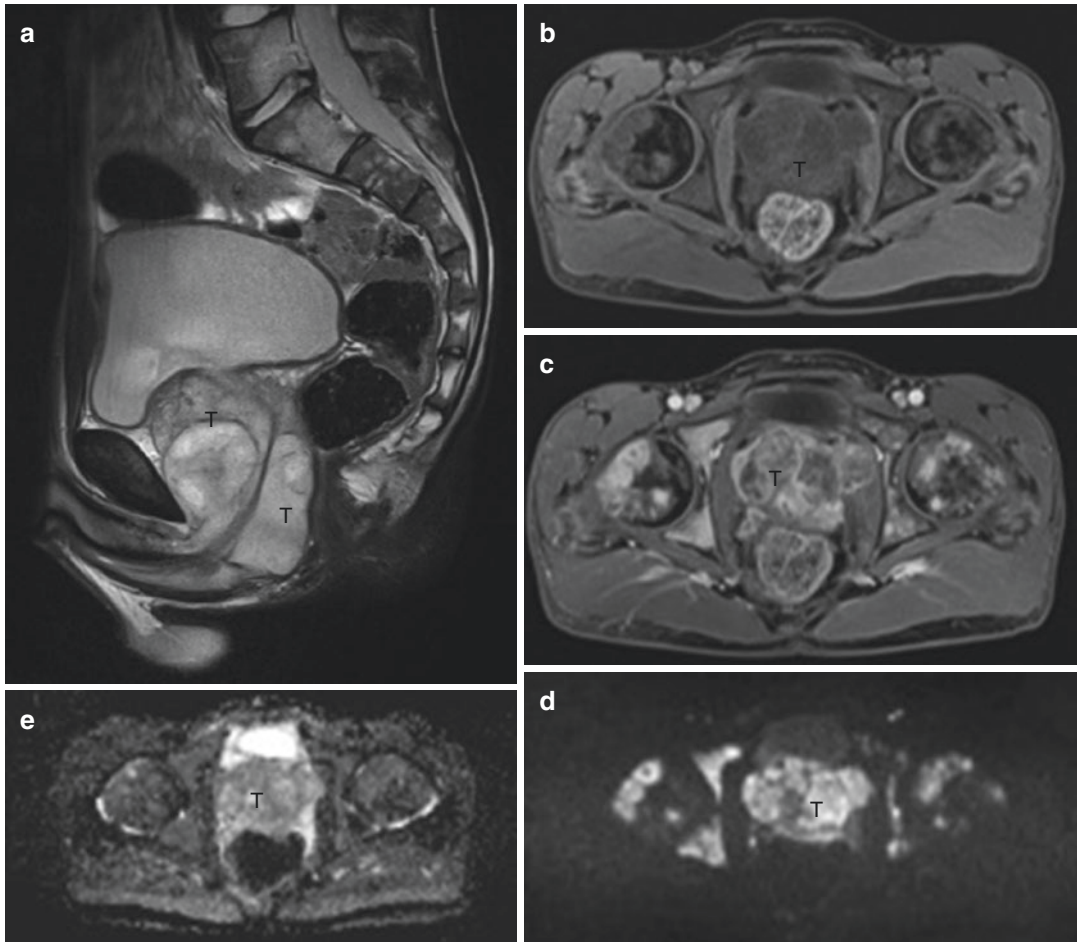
This 16-year-old boy presented with acute urinary retention. There is a lobulated tumor (T) within the prostate, hyperintense on T2-weighted (a), hypointense on fat saturated T1-weighted (b) and heterogeneously enhancing on post-Gd T1-weighted images (c). The tumor shows heterogeneous diffusion restriction on
